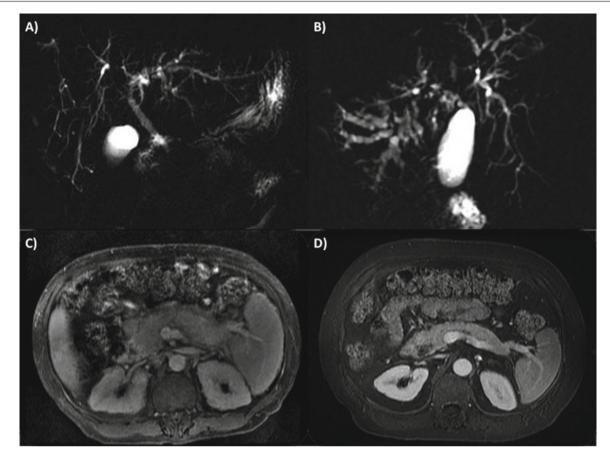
Diagnostic cholangiography in sclerosing cholangitis. Panels (a, b) provide examples of abnormal cholangiograms as evident by MRI, that support the diagnosis of sclerosing cholangitis. Alternate etiologies need excluding before establishing the diagnosis as primary
